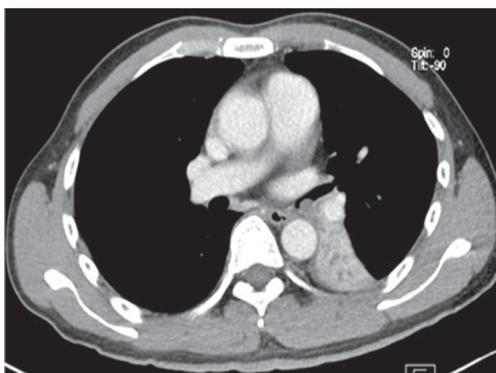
Computed tomography revealed poorly enhancing indeterminate soft tissue in left lower lobe bronchus extending into the distal left main bronchus and causing collapse of the left lower lobe.
